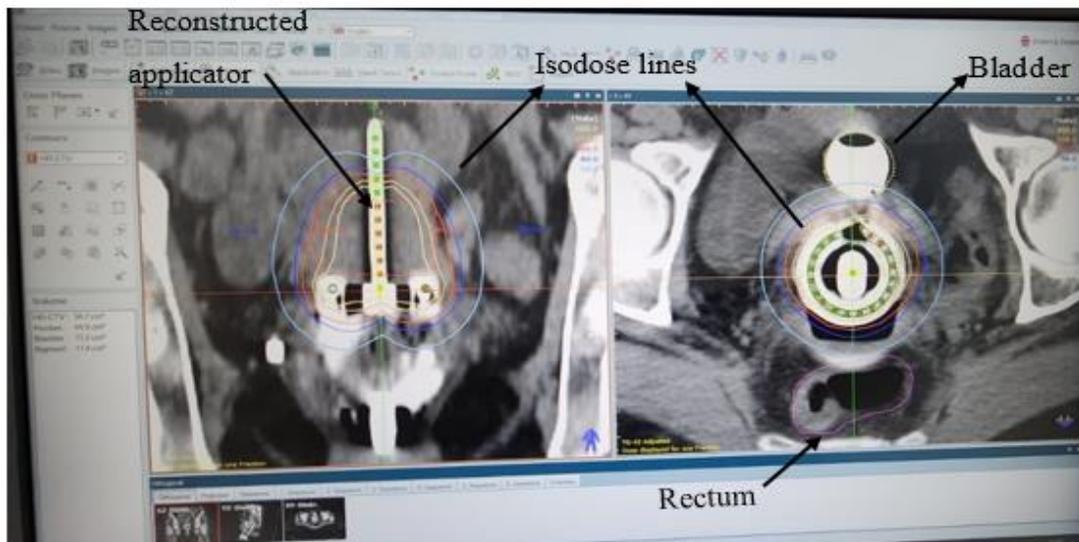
An image showing the dose distribution using isodose lines around the target volume during optimization process on orthogonal radiographs.
